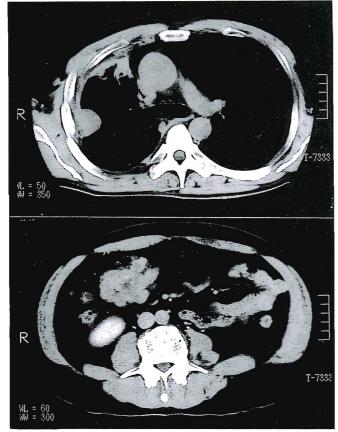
A CT scan of the chest revealing pleural thickening and nodule formation (top) and a CT scan of the abdomen showing a mass in the upper abdomen (right) in March 1997.
